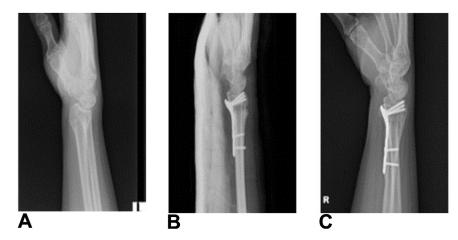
An opening wedge osteotomy was performed on a patient who required correction of sagittal plane deformity because of dorsal tilt. A Preoperative radiograph. B Immediate postoperative radiograph showing an opening wedge osteotomy leading to dorsal tilt correction. C Final follow-up radiograph demonstrating complete osteotomy union.
